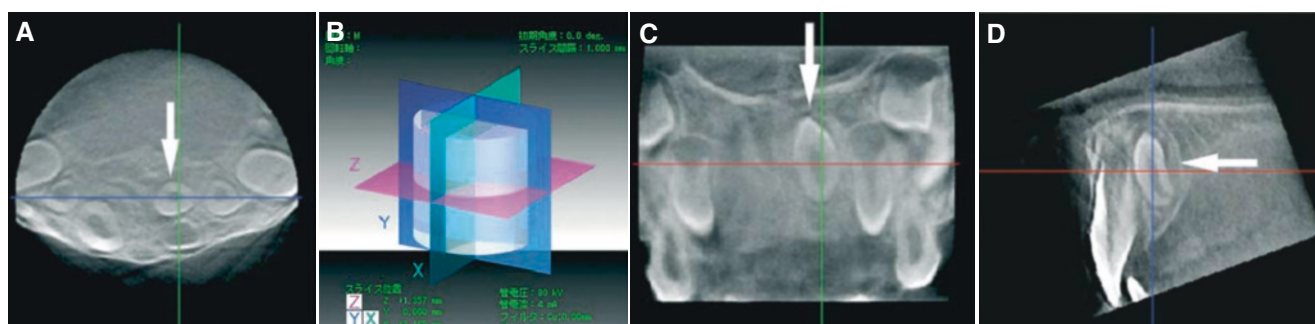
Supernumerary tooth (mesiodens), maxilla; 8-year-old male with incidental finding. (A) Axial CBCT image shows mesiodens (arrow) in palatal position and close to but not in contact with the permanent incisor. (B) Three image planes indicated by different colors.
